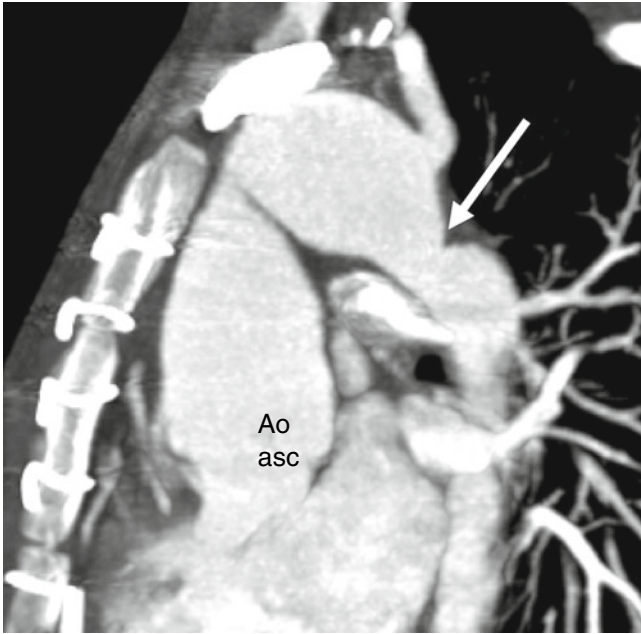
Delayed aneurysm formation in the ascending aorta. A 15-year-old male with a history of surgical repair of a coarctation as a child who presents with increasing hypertension. A computed tomogram shows recurrent coarctation (*arrow*) of the proximal descending aorta at the site of the surgical repair and marked dilatation of the proximal ascending aorta (Ao_{asc})
